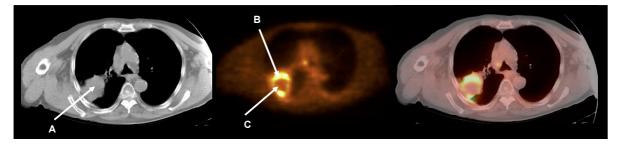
PET (central image) and CT Images (left side image) of a patient with right lung carcinoma CT study shows an abnormal mass (A) that cannot be characterized. The PET study shows glucose uptake in the periphery of the lesion indicating the presence of viable tumour tissue (B) and no uptake in the center, indicating central necrosis. (C) Combining PET/CT (right side image) is ideal for directing the biopsy to the active edge of the lesion.
